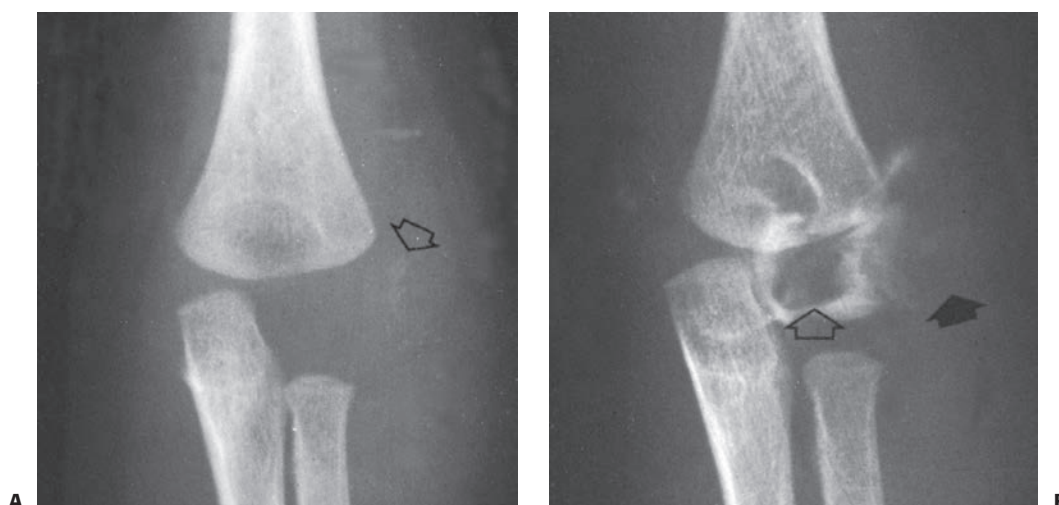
Unossified lateral condyle. A: AP view. A small ossific nucleus can barely be seen (arrow) in the swollen lateral soft tissues. B: An arthrogram shows the defect left by the displaced lateral condyle (closed arrow). The displaced condyle is outlined in the soft tissues (solid arrow). Note the large cartilaginous fragment that is not visible on radiograph.
